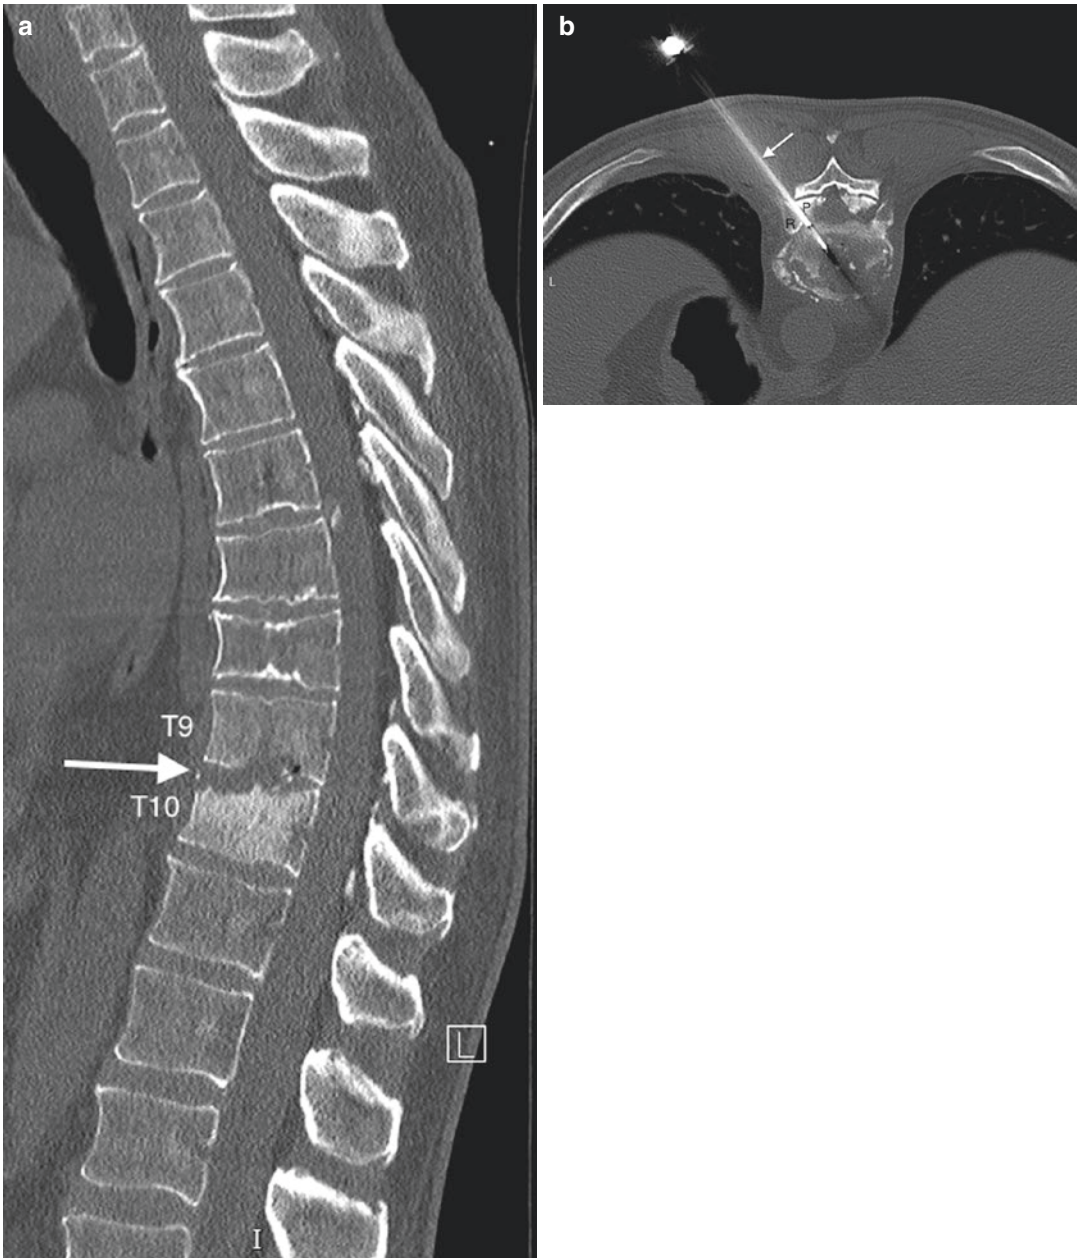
A 65-year-old male with clinically proven acute osteomyelitis, culture positive for *S. aureus*. Reformatted sagittal CT image in bone window algorithm (a) shows irregularity, sclerosis, and erosion of the T9-T10 vertebral endplates (arrow). Axial CT image (b) acquired
